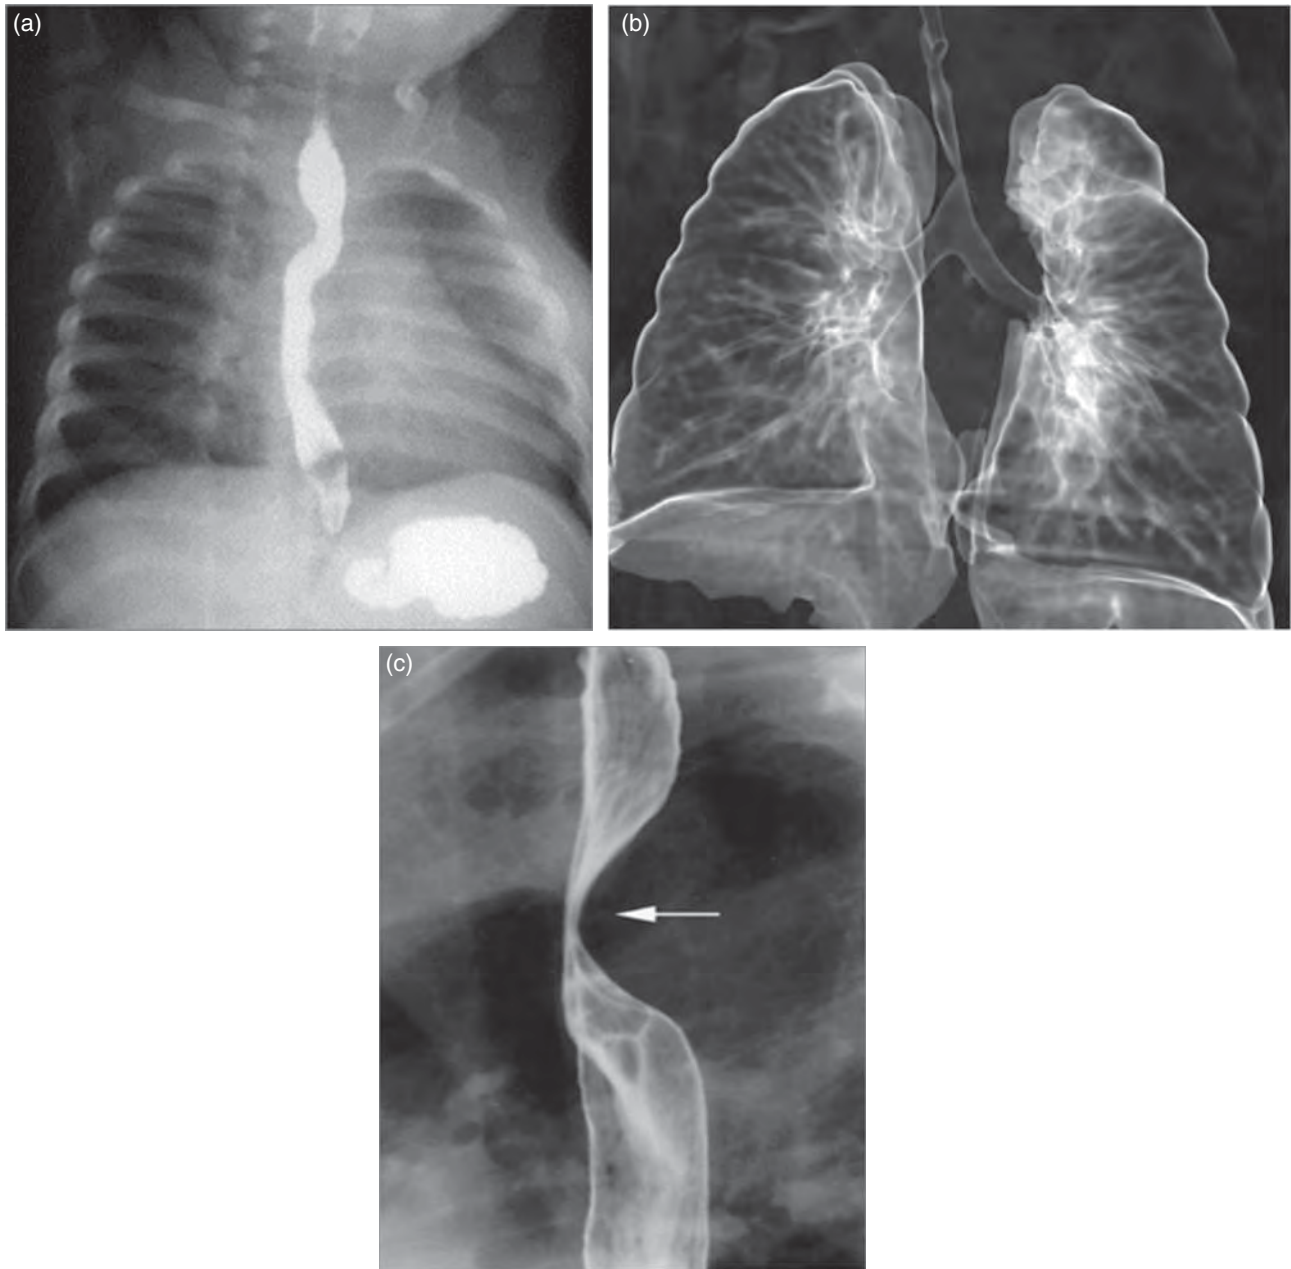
(a) AP view of barium esophagram in a patient with double aortic arch which produces a bilateral indentation of the esophagus. (b) Dynamic tracheal obstruction demonstrated by multidetector CT angiography. (c) Lateral view of barium swallow showing posterior esophageal indentation secondary to a Kommerell diverticulum and anomalous origin of the left subclavian artery.
